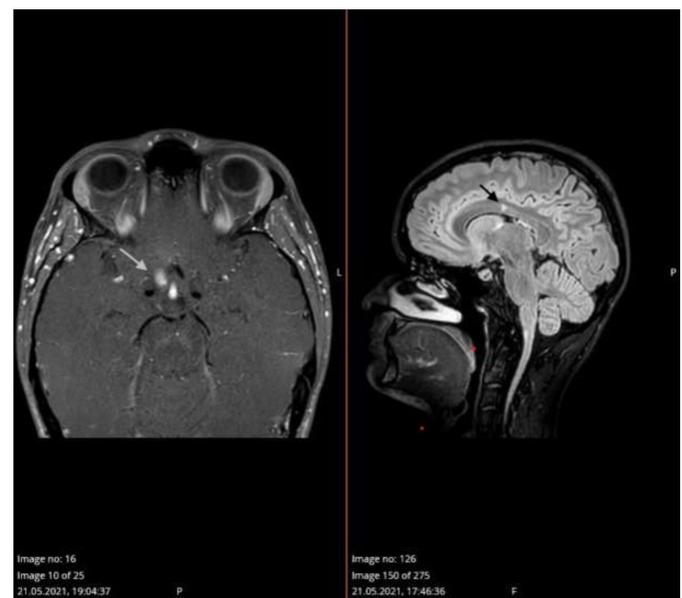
Orbital MRI showing contrast enhancing lesion in the right optic nerve (left) and cranial sagittal MRI showing single ovoid hyperintensity perpendicular to the corpus callosum (right) in T2-weighted images
